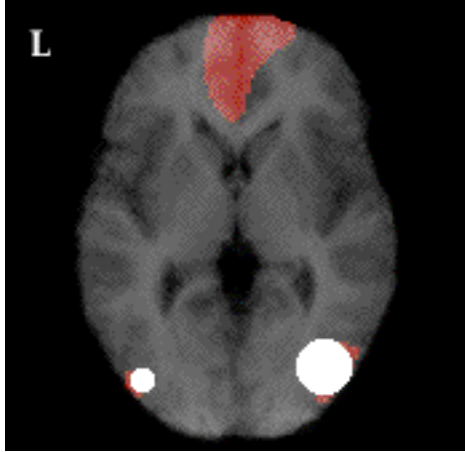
Within-modality auditory priming: Statistical parametric maps (SPM) showing significant decreases in blood flow (shaded white) in the extrastriate (BA 19) areas during within-modality auditory priming as compared to the stem completion baseline. The maps are superimposed over averaged structural MRI images that were transformed to Talairach space.
